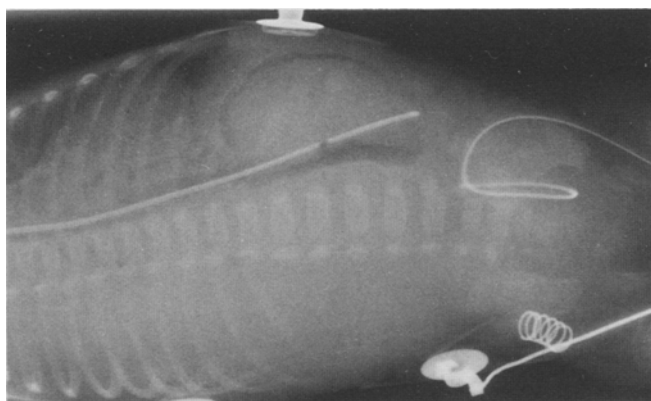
Case 5. Radiograph, with air as a contrast medium, showing a large radio opaque mass in the stomach with the nasogastric tube embedded inside it
